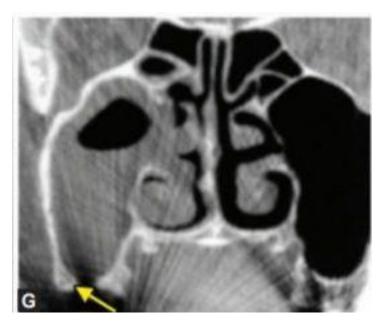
CT scan shows chronic sinusitis and partial opacity in right maxillary sinus, yellow arrow indicating the OAF.
